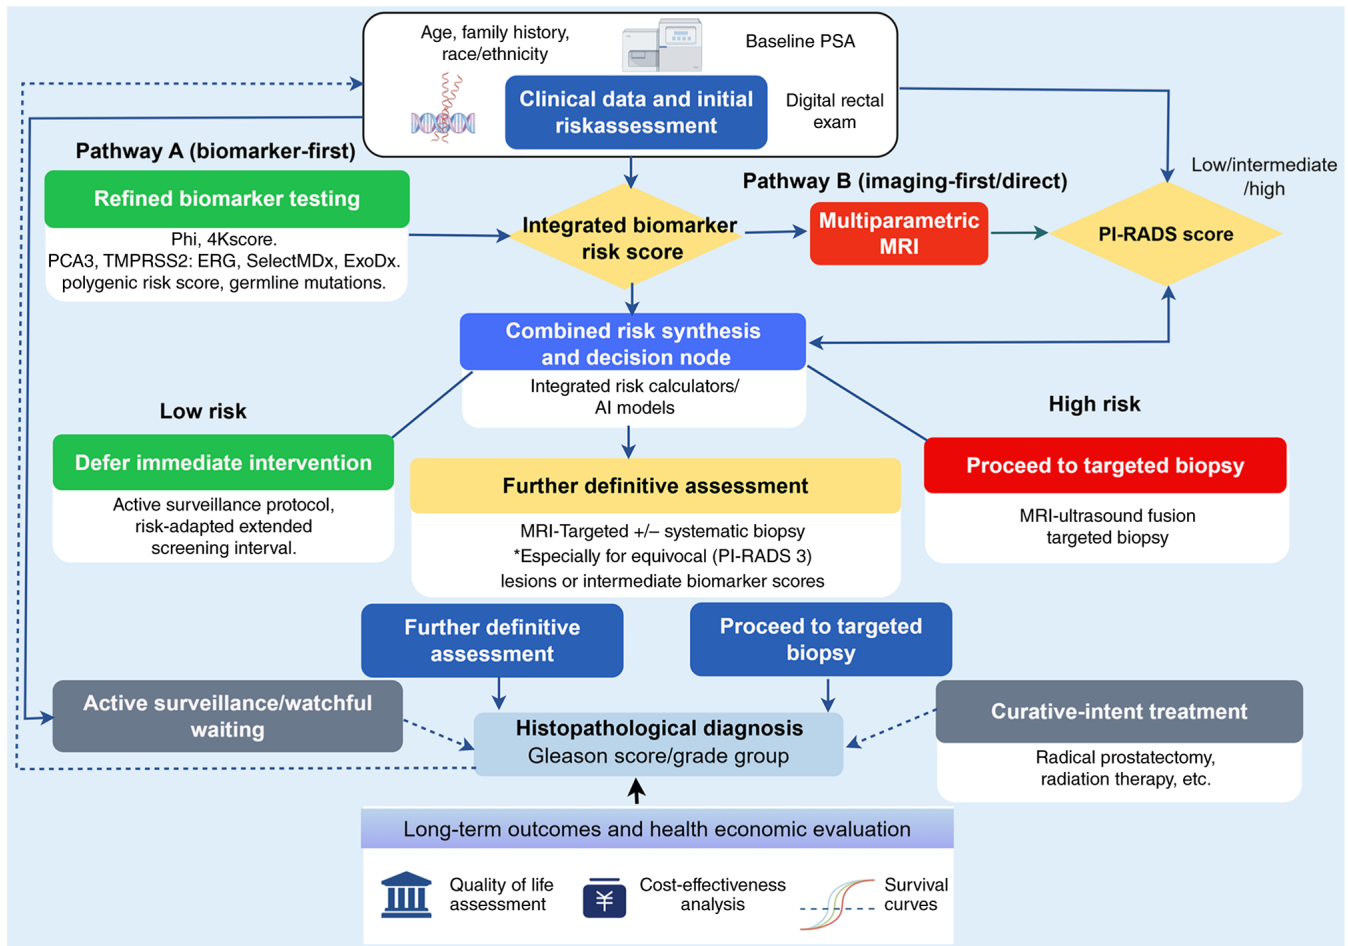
Multimodal, integrated framework for personalized prostate cancer screening and clinical decision-making. This figure outlines a dynamic, biomarker-informed pathway for refining prostate cancer screening. It integrates clinical parameters, novel biomarkers (blood, urine, genetic), and multiparametric MRI within sequential decision nodes to optimize the detection of clinically significant disease while minimizing unnecessary procedures. The framework emphasizes risk-adapted triage, multimodal data synthesis and cost-effective resource allocation, moving toward a personalized screening strategy. Consequently, integrating clinical, biomarker, and MRI data in a sequential, risk-adapted manner enhances detection of clinically significant prostate cancer while reducing overdiagnosis and healthcare costs. This figure was created using the online graphic design website Figdraw (www.figdraw.com). PCA3, prostate cancer antigen 3; PI-RADS, prostate imaging-reporting and data system; PSA, prostate-specific antigen.
